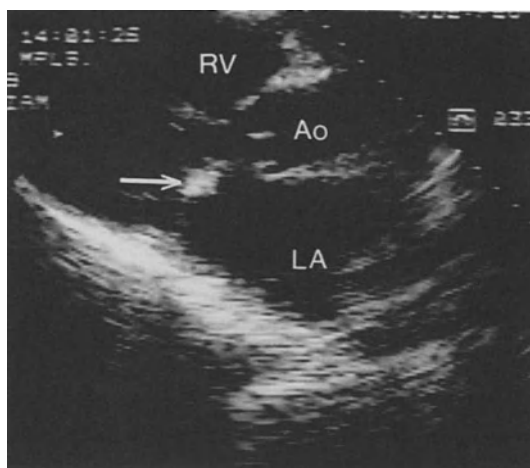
Two-dimensional echocardiogram showing vegetation on anterior leaflet of the mitral valve (arrow).
